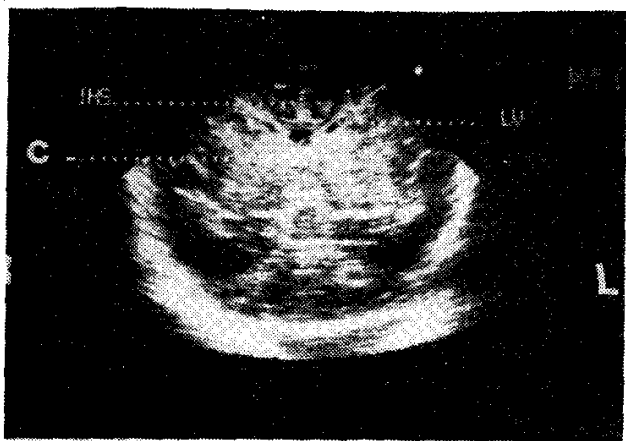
Coronal sonogram at level of head of the caudate nucleus showing normal lateral (LV) and cavum septum pellucidum (c).
